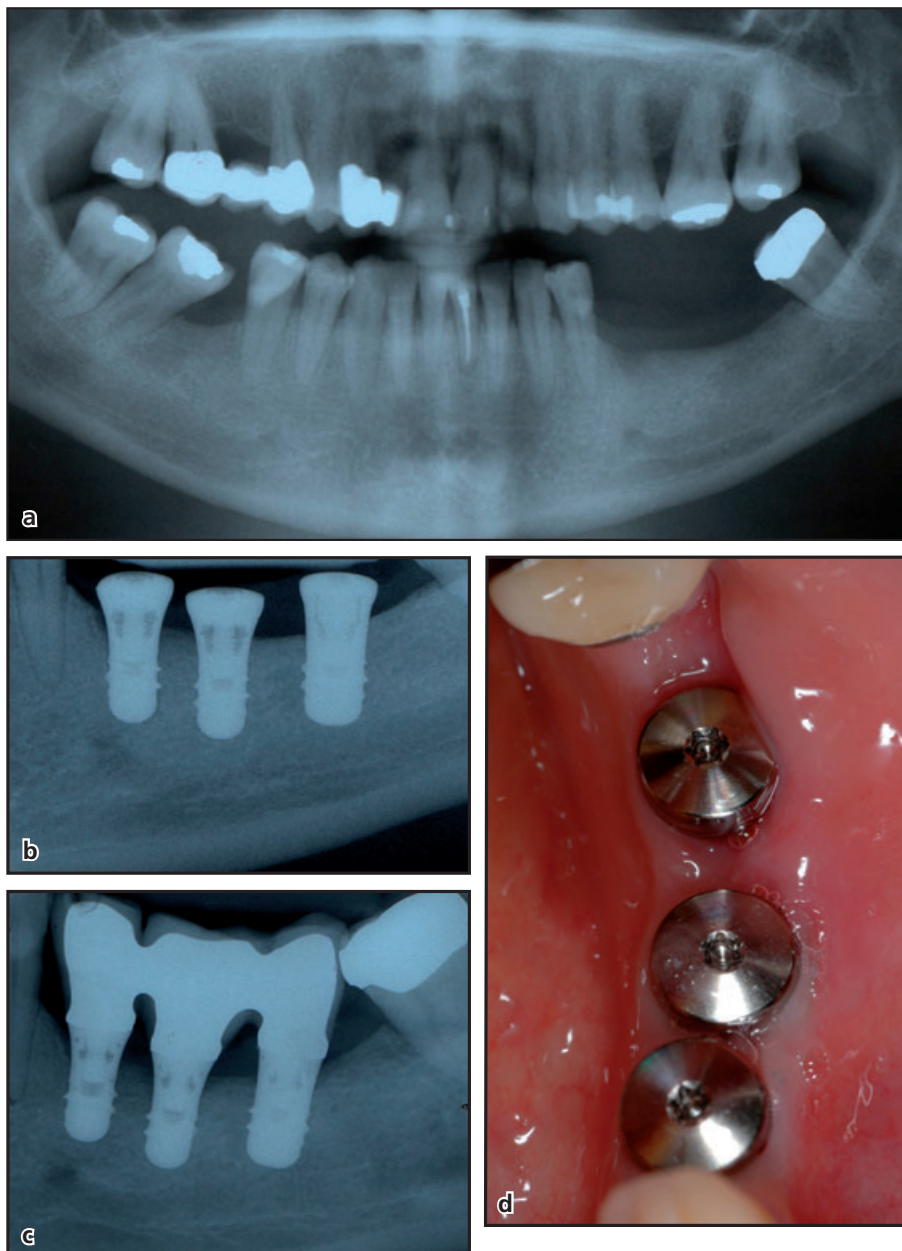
Mandibular edentulous area after the extraction of teeth 35, 36 and 37. (a) Orthopantomogram revealing the neighboring anatomic structures (inferior mandibular nerve) and intact reconstructions on the teeth adjacent to the edentulous ridge. (b) Installation of two standard (4.1 mm diameter) and one wide-body (4.8 mm diameter) Straumann® implants at a distance of 5 mm, 11 mm and 20 mm distal to the distal aspect of tooth 34. (c) Transmucosal implant installation for two premolar and one molar unit. Implants covered with healing caps. The intact crown on tooth 38 is visible. (d) Radiographic documentation after 5 years. Implant crowns are splinted because of the short (6 mm) implants (in the neighborhood of the inferior mandibular nerve).
